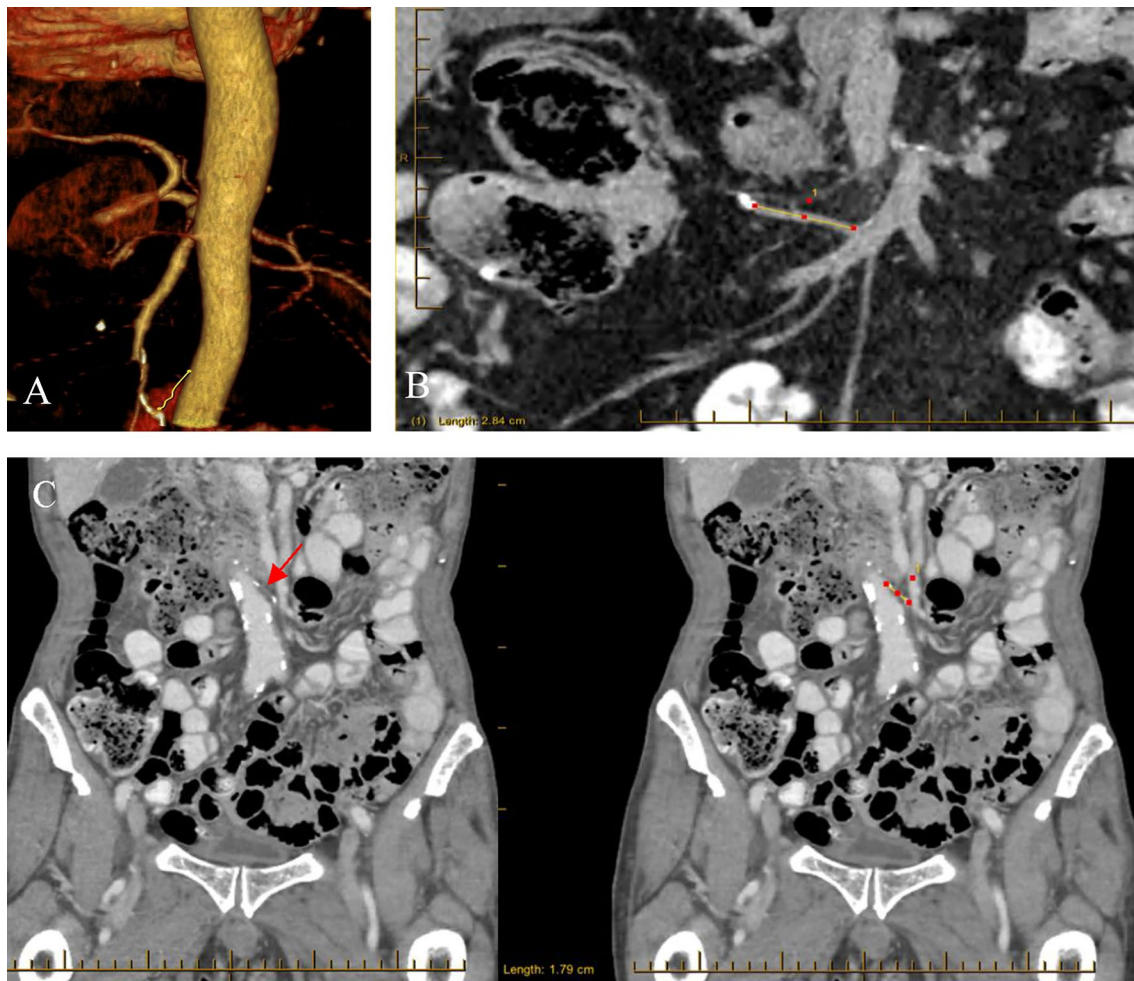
A Coronal volume-rendered reformat CT image of the IMA RAPL, defined by its termination at a surgical clip; B Multi-planar reconstructed (MPR) CT image with ICA RAPL defined and measured in the coronal plane; C MPR CT image with IMA RAPL defined
